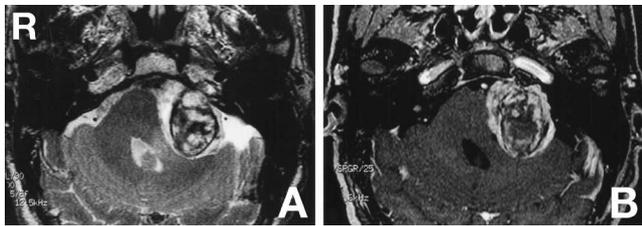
Preoperative T_2 -weighted magnetic resonance image (A) demonstrating a mass 35 mm in diameter in the left cerebellopontine angle as a heterogeneous area associated with hypointense rim within the tumor, indicating intratumoral hemorrhage, and T_1 -weighted image with contrast medium (B) showing strong enhancement of the circumference of the rim.
